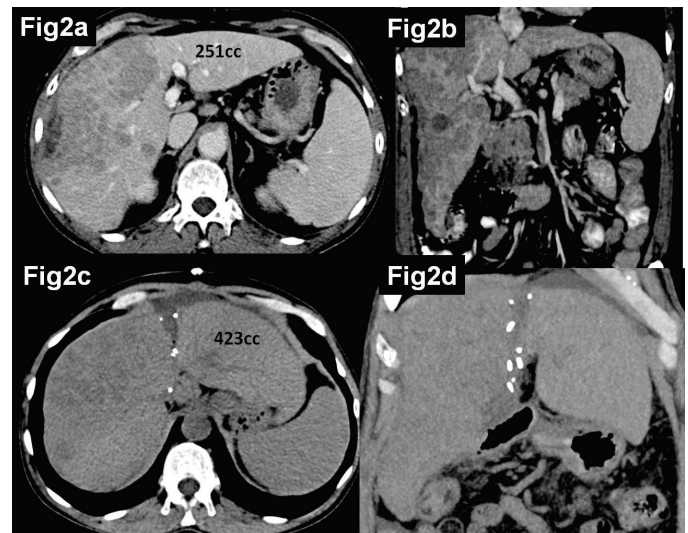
(a and b) Preoperative CT scan showing FLR volume of 251cc, 19% of total liver volume. (c and d) CT scan after 13 days of first stage hepatectomy showing the liver partition and hypertrophied left lateral segment with a volume of 423cc, 41% of total liver volume.
